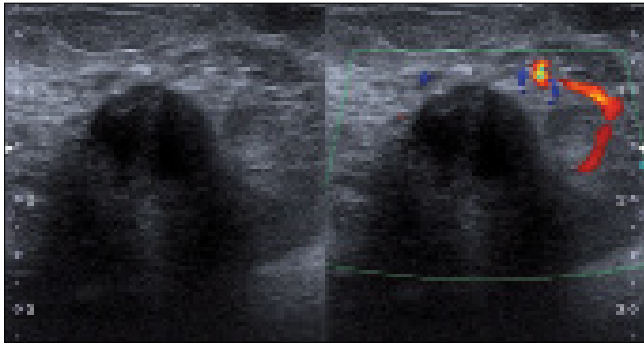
Ultrasonographically-solid, heterogeneous, hypoechoic, peripherally-vascularized mass with posterior enhancement
